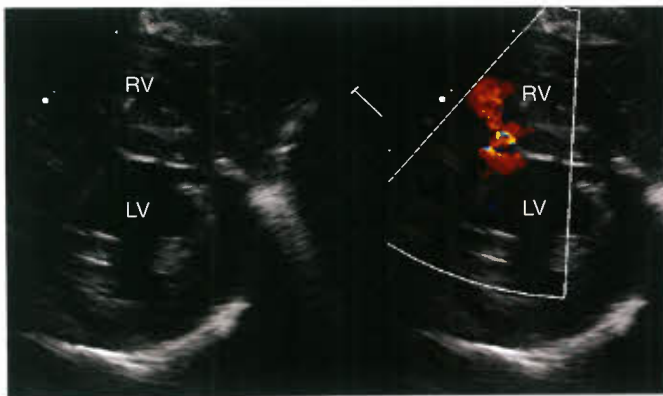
Parasternal short-axis imaging plane at the level of the papillary muscles demonstrating two-dimensional and color Doppler left-to-right flow across a midmuscular VSD.
